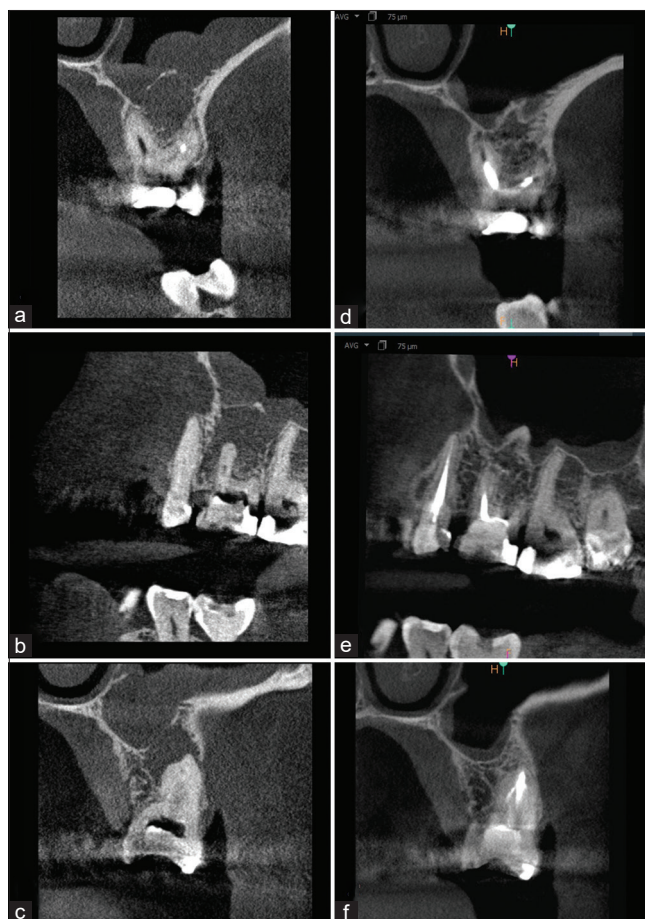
(a-c) Preoperative sagittal and coronal cross-sections of 26 tooth show chronic apical periodontitis coexisting with maxillary sinusitis of endodontic origin with periapical osteoperiostitis and periapical mucositis symptoms; (d-f) 1-year control cone-beam computed tomography systems shows complete reconstruction of bone and resolution of sinusitis symptoms.
